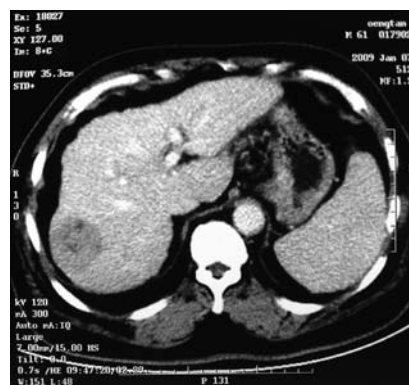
Computed tomography (CT) image before operation, which showed the lesion on the right lobe of the cirrhotic liver.
